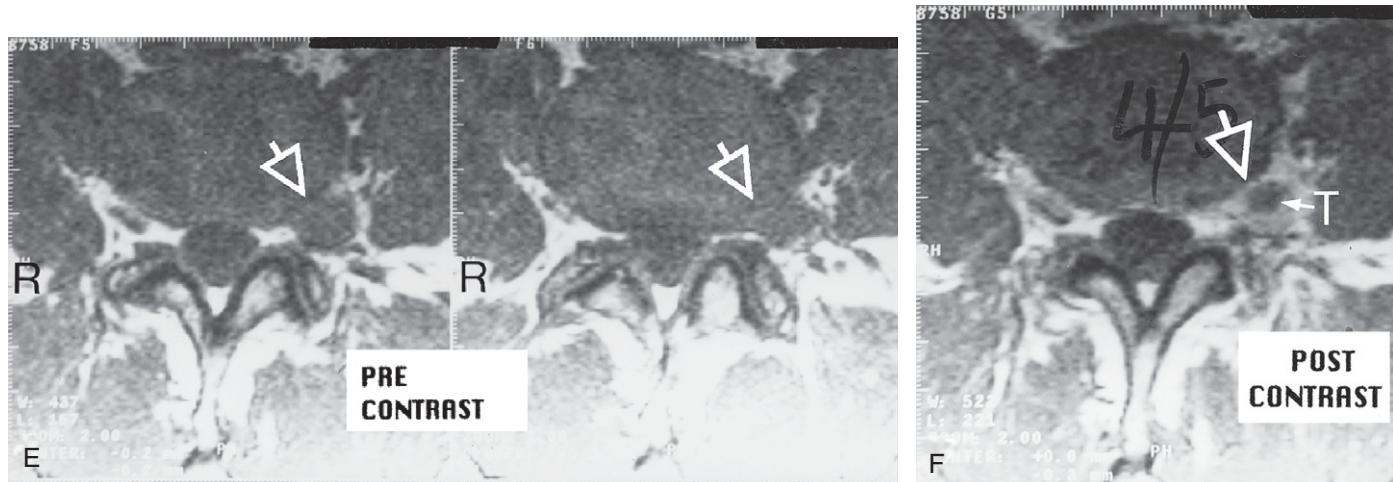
Cont'd (E) Axial T1-weighted pre-contrast MRI scan at the L4–5 disc area. The arrow shows apparent continuity between disc material and the far lateral 'lesion'. (F) Lumbar spine MRI axial T1-weighted post-contrast scan at the L4–5 disc area. The arrow clearly shows there is no continuity between the tumour (T) and the disc material.
